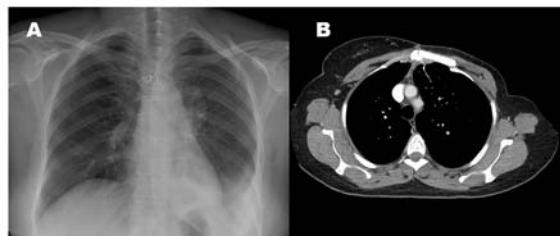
(A) Chest x-ray showing prosthesis in place and sternal wires. (B) CT scan of the chest showing prosthesis in situ
